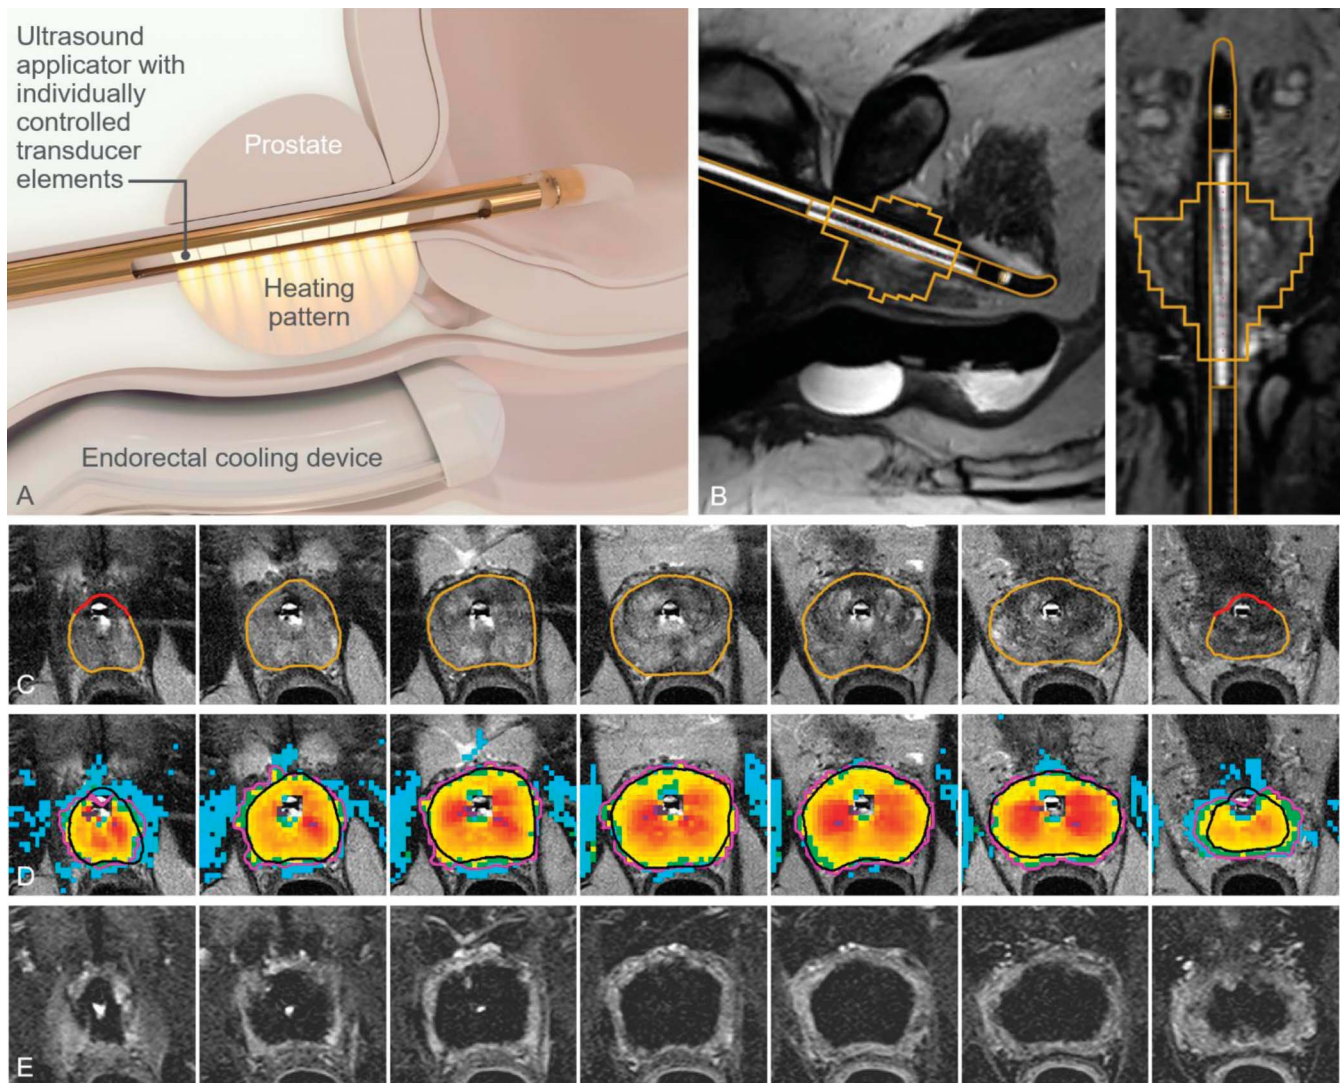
TULSA procedure. *A*, rendering of ultrasound applicator and endorectal cooling device. *B*, sagittal and coronal views of 3D T2-weighted image of ultrasound applicator and planned ablation zone. *C*, ablation zone prescribed on intraoperative axial T2-weighted images from prostate apex to base. *D*, MRI temperature map depicting maximum temperatures achieved during treatment. *E*, enhancement defect confirms ablation extent on posttreatment contrast enhanced T1 weighted images.
